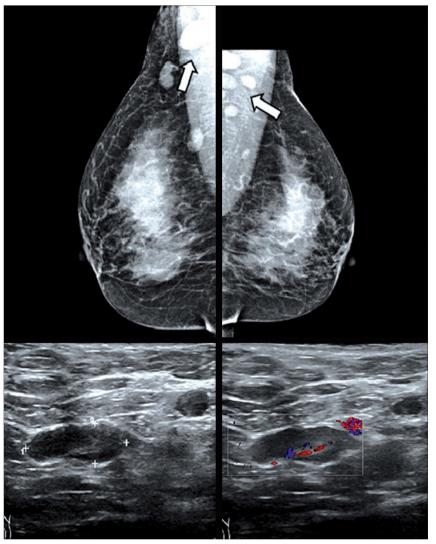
Multiple bilateral, enlarged, dense lymph nodes were detected on a screening mammogram of a 48-year-old woman with HIV (*arrows*). Transverse and oblique US and Color Doppler of the bilateral axillae show hypoechoic, round lymph nodes with central flow.
